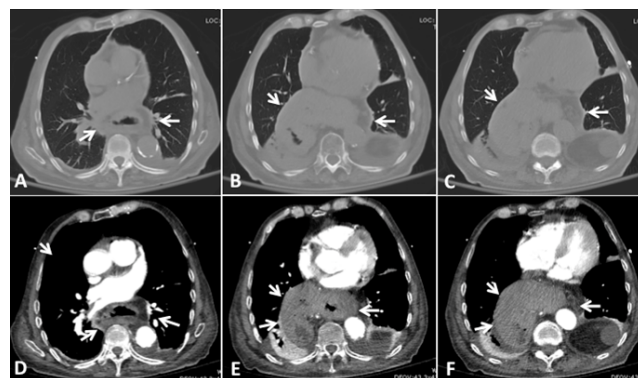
Representative transaxial slices of the thoracic CT at superior, mid and lower level of the mediastinum (images A-C without contrast and D-F following iv contrast injection). These images show herniation of the entire stomach into the retro-cardiac space. The radiological appearance is consistent with organo-axial volvulus of the stomach
